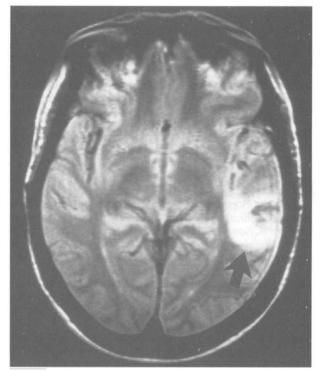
MRI with gadolinium (axial cut) showing left temporal lobe haematoma (arrow).
